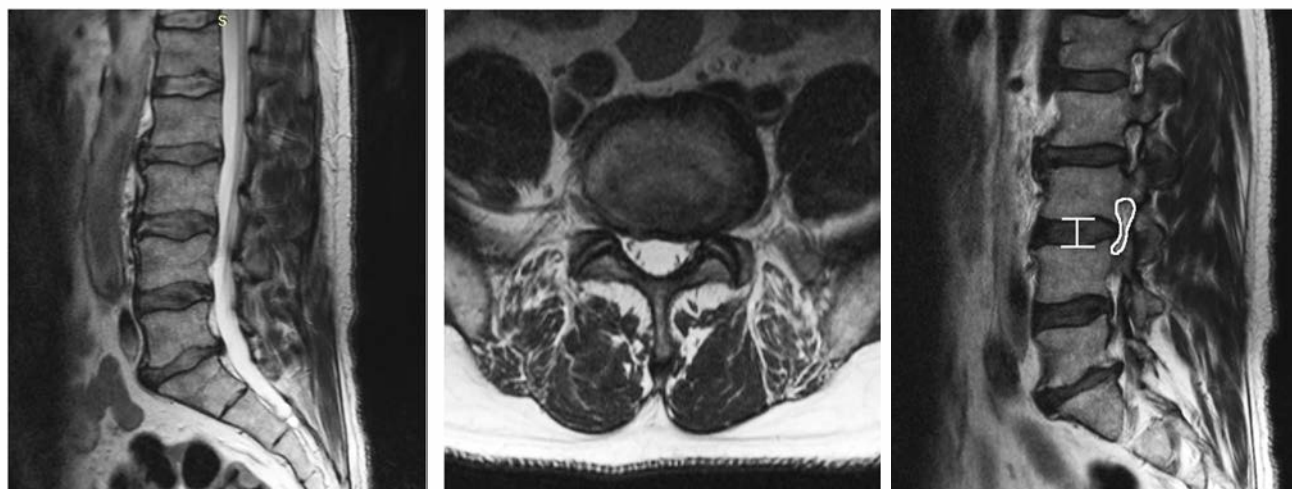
Preoperative MRI of the lumbosacral spine showing the herniated disc on L_{III} - L_{IV} level with caudal fragment migration. (A) – sagittal T2-weighted image; (B) – axial T2-weighted image; (C) – intervertebral disc height (9.4 mm) and foraminal area on the sagittal image (107 mm^2)
